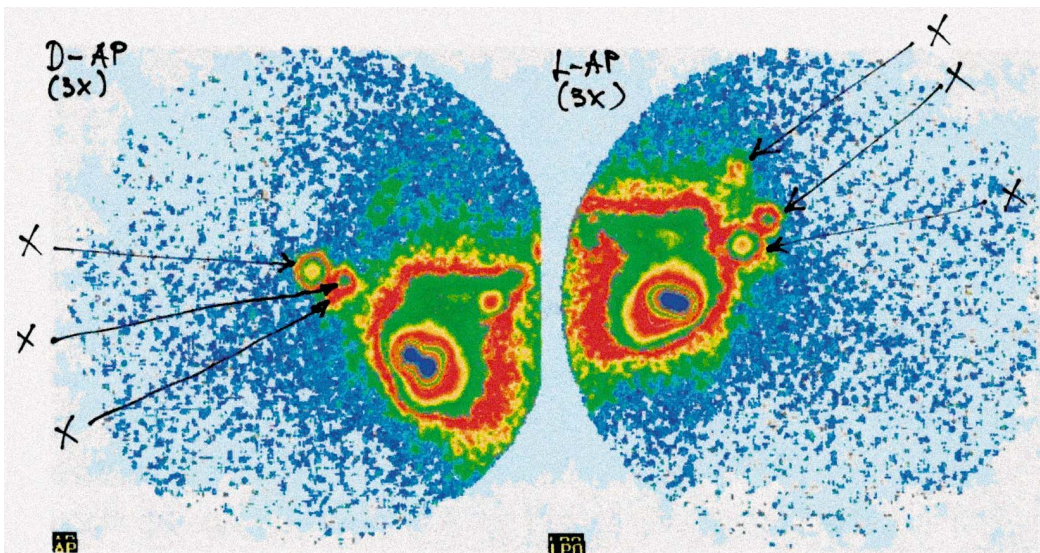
Vulvar static lymphoscintigraphies with ^{99m}Tc nanocolloid.
